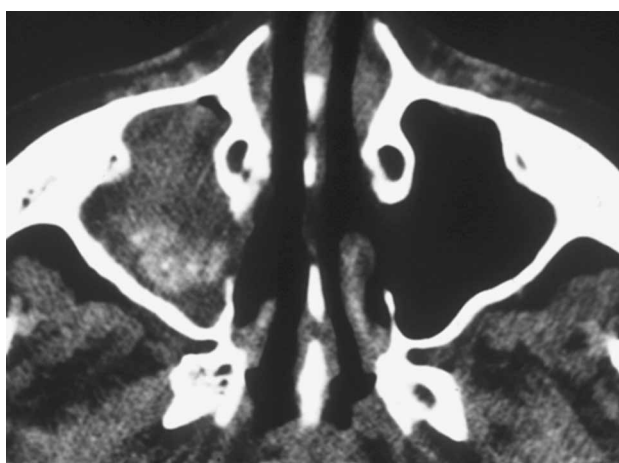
Computed tomographic scan. Axial view showing micro-opacities and a thickening of the walls of the right maxillary sinus cavity.
